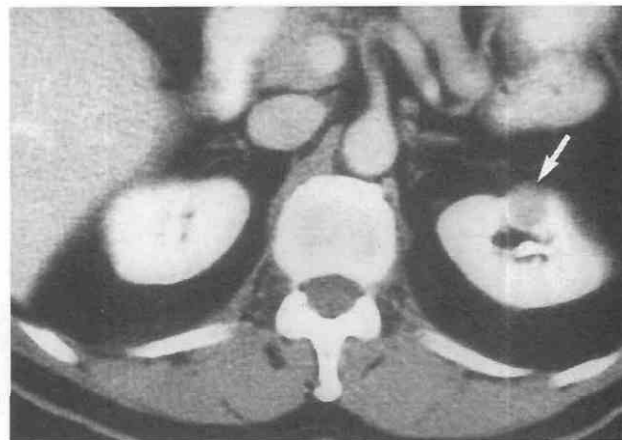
Small (1.8-cm) renal cell carcinoma (arrow) detected incidentally by CT.
